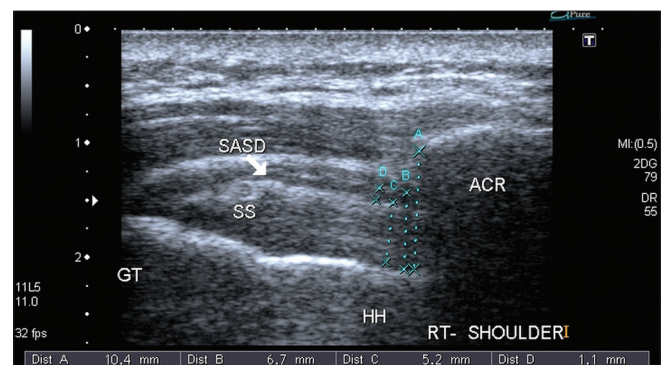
Ultrasound image of the right normal shoulder in neutral arm position of a 39-year-old male. (A) Subacromial space, (B) Subacromial contents, (C) Supraspinatus tendon thickness, (D) Subacromial subdeltoid bursa. The Subacromial contents to subacromial space ratio is 0.64 while there is no impingement syndrome, and negative by dynamic sonography for SIS. Key: HH: Humeral head, SASD: Subacromial subdeltoid bursa, GT: Greater tuberosity, ACR: Acromion, SS: Supraspinatus tendon, SIS: Subacromial impingement syndrome
